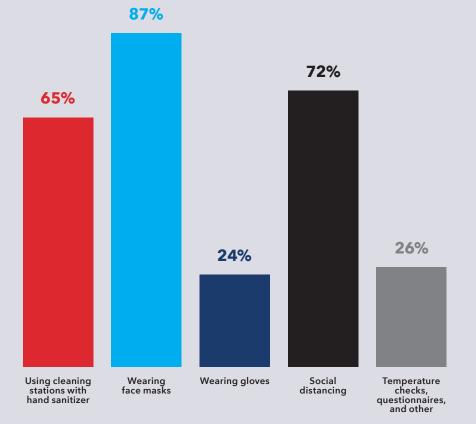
SAFETY REQUIREMENTS DURING INSPECTIONS
